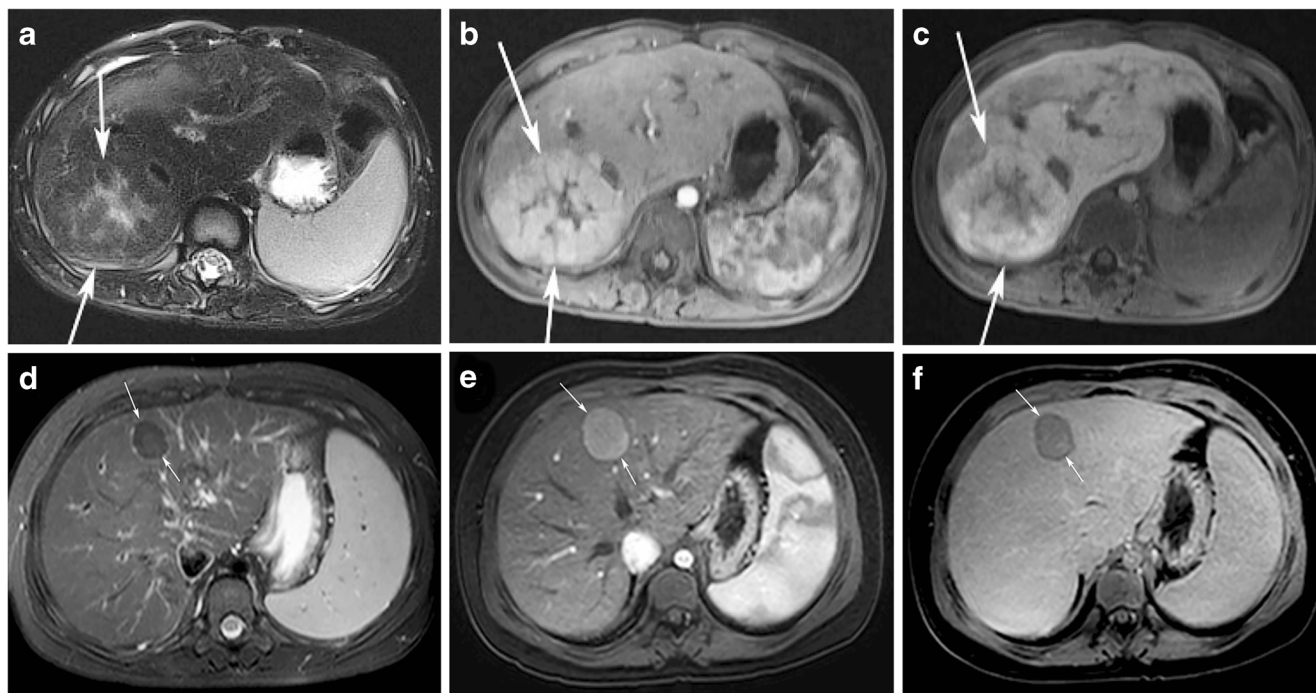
Hepatobiliary MR imaging using gadoxetic acid. T2-weighted fat-suppressed (a, d) and arterial phase (b, e) and 20-min hepatobiliary phase post-contrast (c, f) images. a–c Focal nodular hyperplasia in an 8-year-old girl demonstrates a T2-weighted hyperintense central scar (a, arrows), avid arterial-phase enhancement (b) and hepatobiliary contrast
